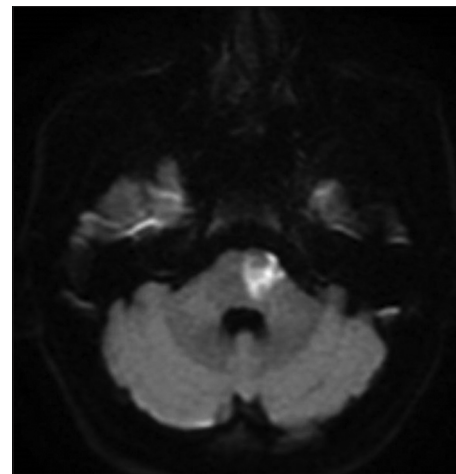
Cerebral magnetic resonance imaging showing on diffusion-weighted imaging ischemic lesions of the pons involving the ventral surface in the territory of the paramedian pontine artery
